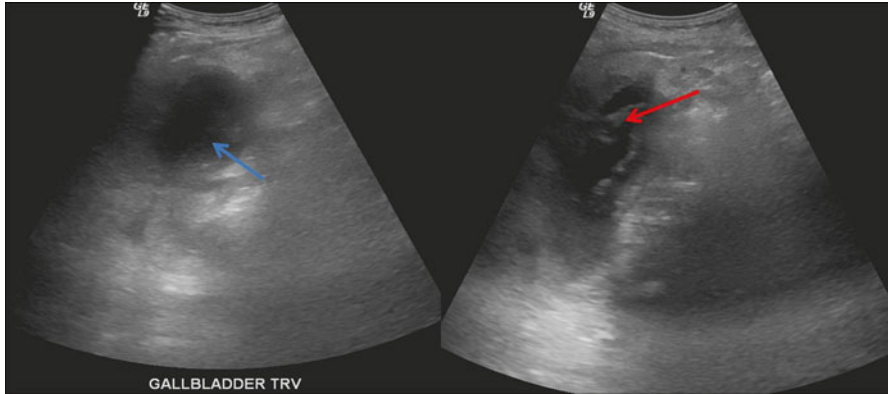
Acute Cholecystitis. Axial (*left panel*) and sagittal (*right panel*) of right upper quadrant gray scale ultrasound images in a 56 year old male with right upper quadrant pain and fever demonstrates gallbladder wall thickening of 0.43 cm (*red arrow*), well above the normal maximum of approximately 0.2–0.3 cm and pericholecystic fluid (dark area above the *red arrow*) in keeping with an acute cholecystitis. Note the intraluminal echogenic material, which probably represents sludge (*blue arrow*)
